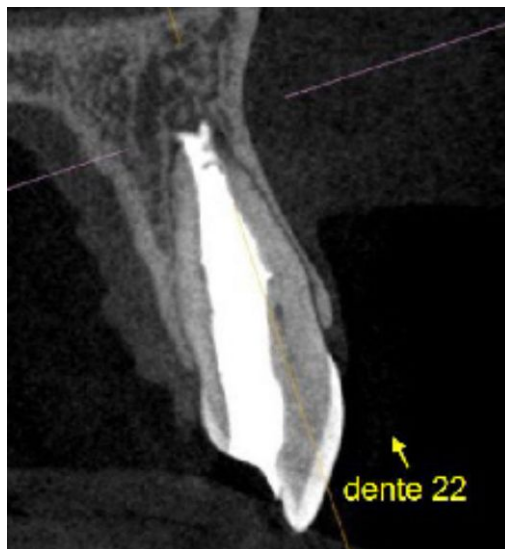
CBCT follow-up after 14 months.
